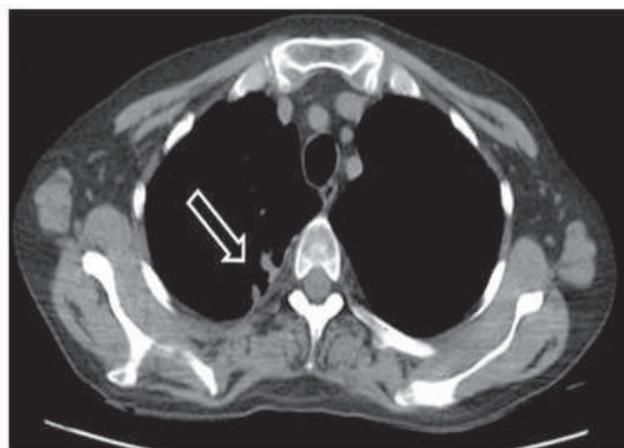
Control thorax computed tomography image was normal after medical treatment (white arrow).
